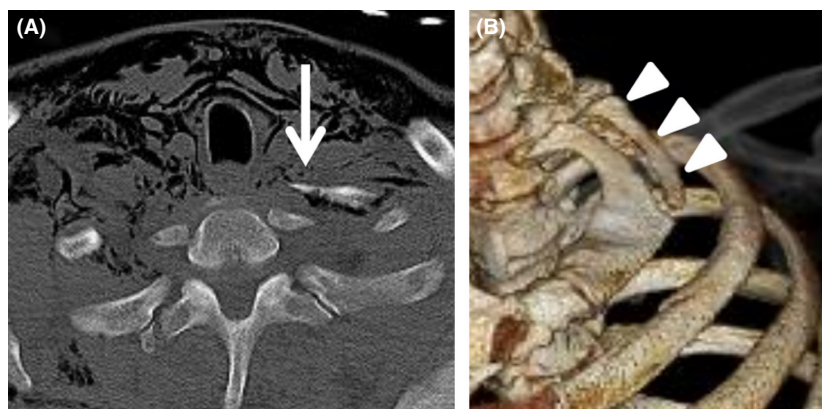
Chest CT (A) and 3D-CT (B) image on admission. Posterior fragment of the fractured first rib with its sharp edge (A, arrow) and with dislocation (B, arrowheads) is shown.
